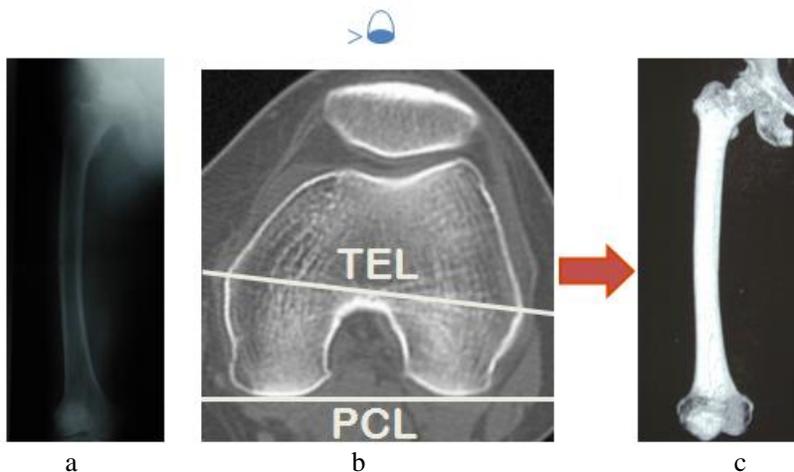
It is difficult to take a radiograph in neutral rotation perpendicular to PCL clinically (a). By using 3-dimensional computer tomography (3-D CT), it may be easy to evaluate femoral configuration in neutral rotation perpendicular to PCL (b and c).
